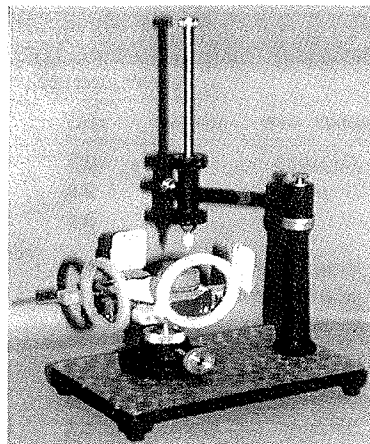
Customized dental surveyor with fabricated radiographic jig and tissuelike substance container.
